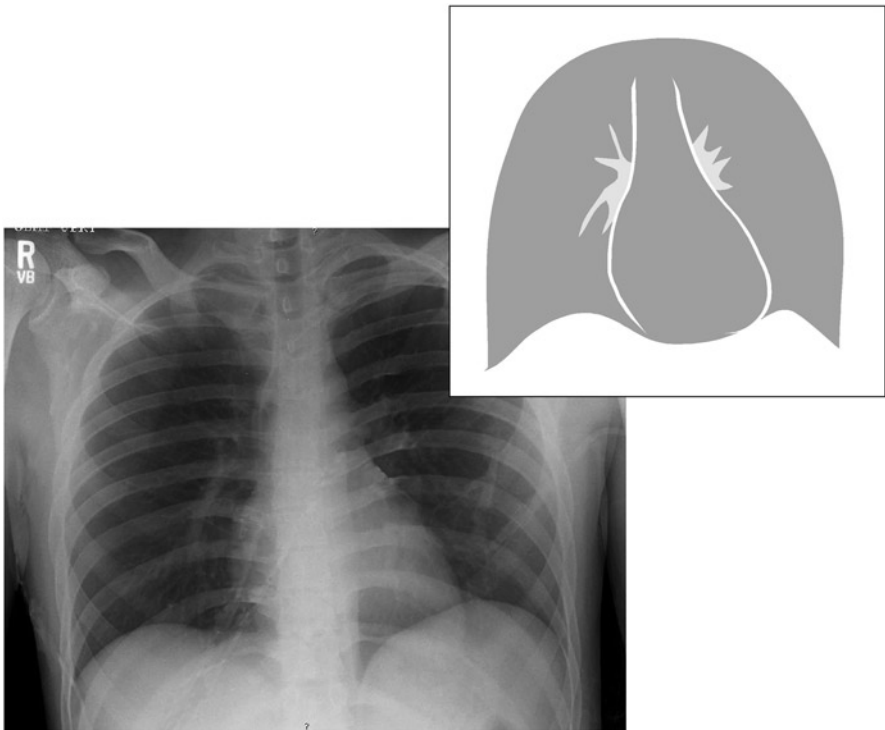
Normal chest X-ray: The cardiac silhouette is normal in size and contour. A normal pulmonary blood flow pattern is present with no evidence of pleural disease
